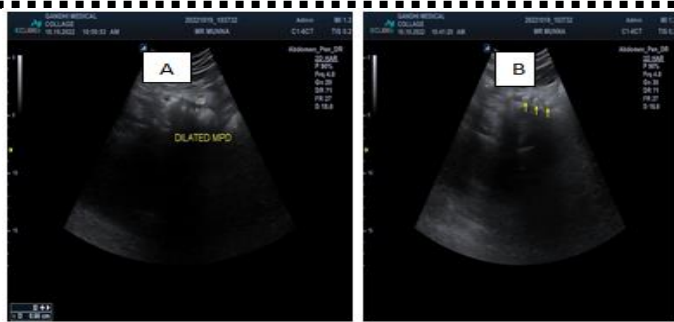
Ultrasound shows multiple tiny calcifications (arrows in B) in pancreas with dilated main pancreatic duct (arrow in A).
